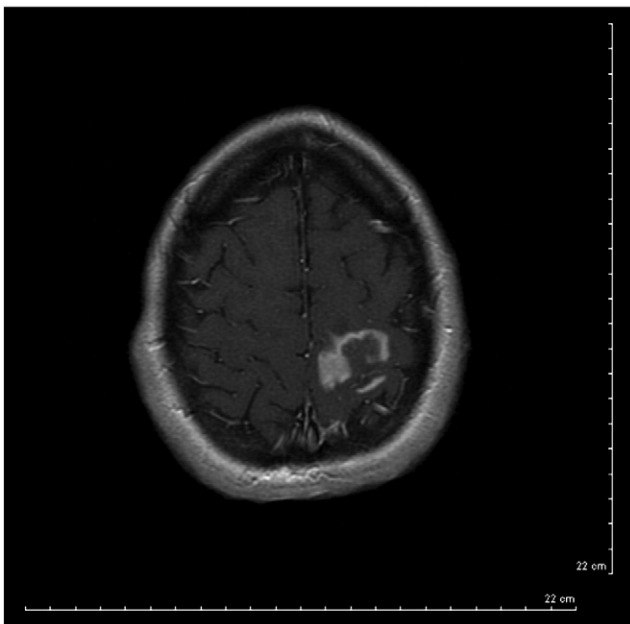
Contrast T1-weighted axial MRI examination of the brain demonstrated a 3.0-cm intraaxial mass in the left parietal lobe with an open-ring enhancement pattern directed toward the cortical surface. This pattern is frequently encountered with tumefactive MS. There was minimal mass effect.
